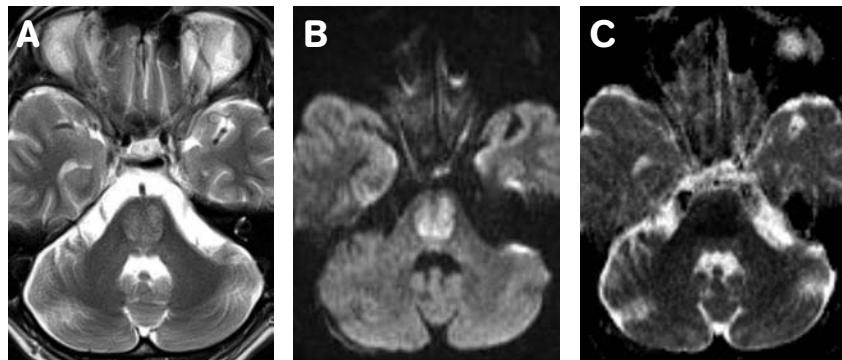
(A) Axial T2WI MR shows a high signal area in the central pons sparing the peripheral white matter, which is a classical finding of central pontine myelinolysis. (B, C). Axial DWI and ADC-map MR show diffusion restriction, with a pattern that precisely matches the hyperintensity on the T2WI.
